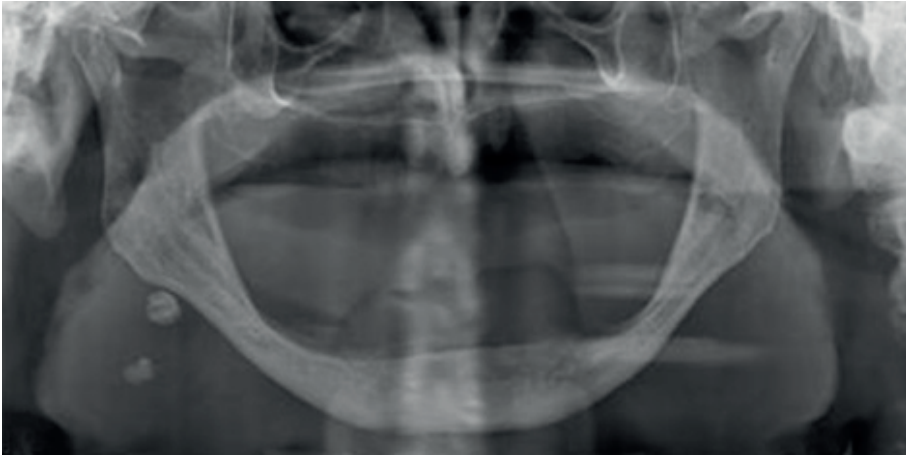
Panoramic radiograph of an edentulous patient with sialoliths in the right submandibular gland (courtesy of professor Johan Aps, University of Washington, School of Dentistry)
